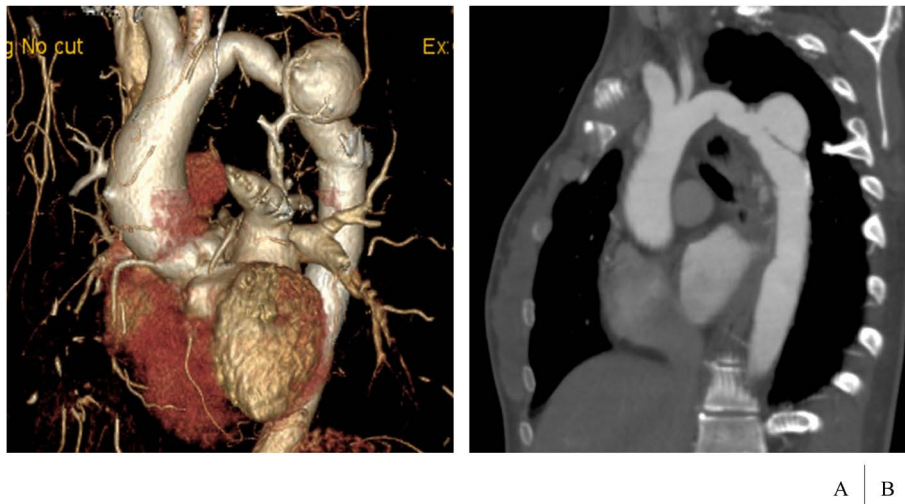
Preoperative computed tomography scan showing a 42-mm-diameter pseudoaneurysm in the distal aortic arch (A, B).
